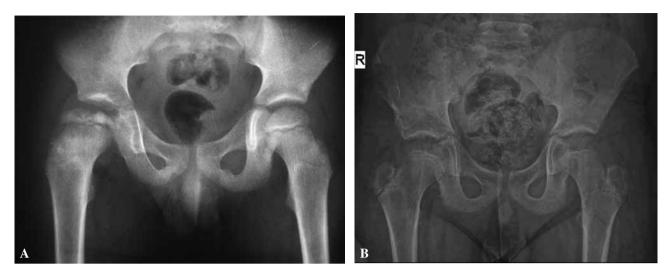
A : 7-year-old male, right hip, Herring type B, Preoperative AP radiograph. B : Postoperative radiograph at 5 years. Stulberg I, HHS : 100.
